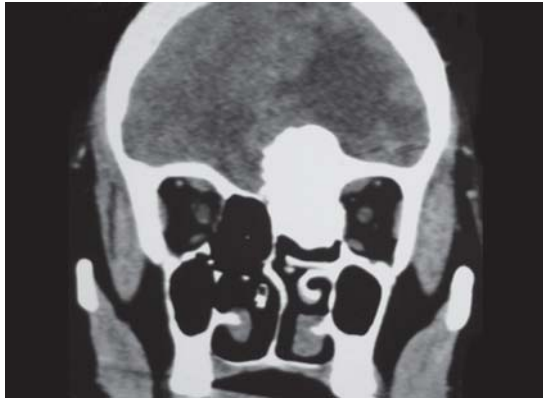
Coronal CT scan showing left frontoethmoidal osteoma with intracranial extension
